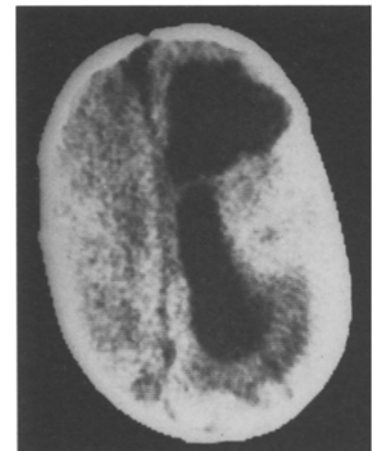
CT of brain demonstrating severe dilatation of the anterior and occipital horns of the right lateral ventricle, and midline shift to the left
